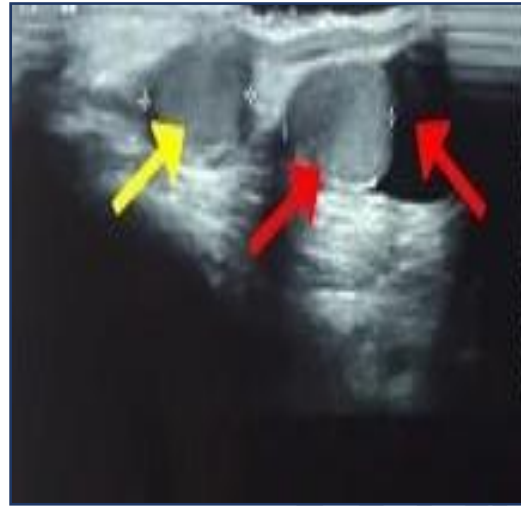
Ultrasonography showing two testes in right hemiscrotum
